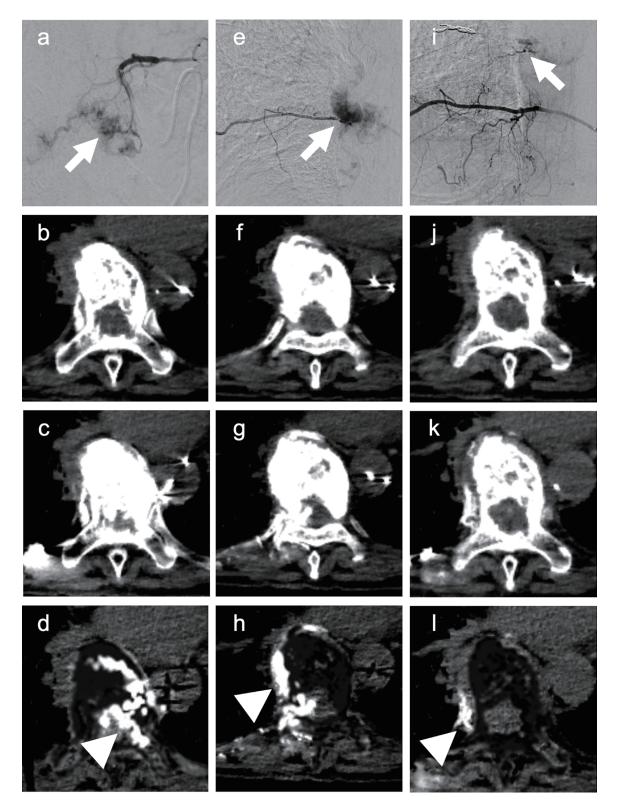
Renal cell carcinoma in a 70-year-old woman. Spinal metastasis was found in the eighth thoracic vertebra. Images of DSA ($\mathbf{a}, \mathbf{e}, \mathbf{i}$), unenhanced CT ($\mathbf{b}, \mathbf{f}, \mathbf{j}$), ns-CTA ($\mathbf{c}, \mathbf{g}, \mathbf{k}$), and s-CTA ($\mathbf{d}, \mathbf{h}, \mathbf{l}$) after selection of intercostal arteries ($\mathbf{a}-\mathbf{d}$: left 7th, $\mathbf{e}-\mathbf{h}$: right 8th, $\mathbf{i}-\mathbf{l}$: right 9th) are shown. Tumor enhancement is identified in DSA (arrows in \mathbf{a}, \mathbf{e} , and \mathbf{i}). Enhancement of a part of the surgical invasion zone in the tumor is more clearly identified by s-CTA (arrowheads in \mathbf{d} and \mathbf{h}) than by ns-CTA (\mathbf{c} and \mathbf{g}) prior to embolization. Contrastingly, it is more clearly identified by s-CTA (arrowhead in \mathbf{l}) when enhancement does not include the surgical invasion zone than by ns-CTA (\mathbf{k}). Therefore, embolization was not adopted. CT, computed tomography; DSA, digital subtraction angiography; ns-CTA, non-subtraction computed tomography arteriography.
